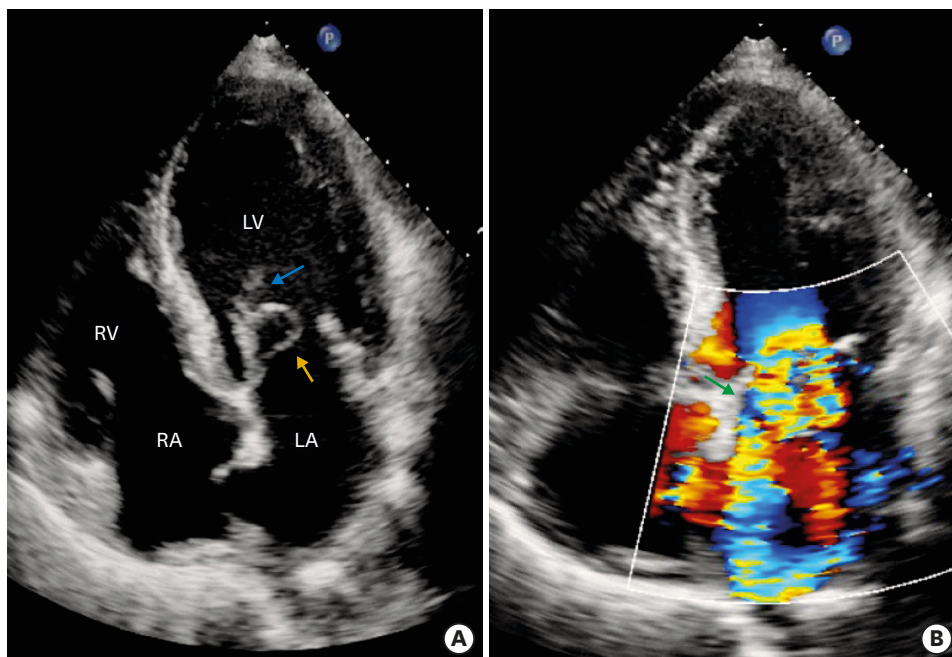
Transthoracic echocardiogram (apical 4-chamber view). (A) Saccular bulge on the atrial side of the anterior mitral valve leaflet (orange arrow) and vegetations (blue arrow). (B) Color Doppler image showing mitral regurgitation jet through the ruptured aneurysm (green arrow). LA: left atrium, LV: left ventricle, RA: right atrium, RV: right ventricle.
